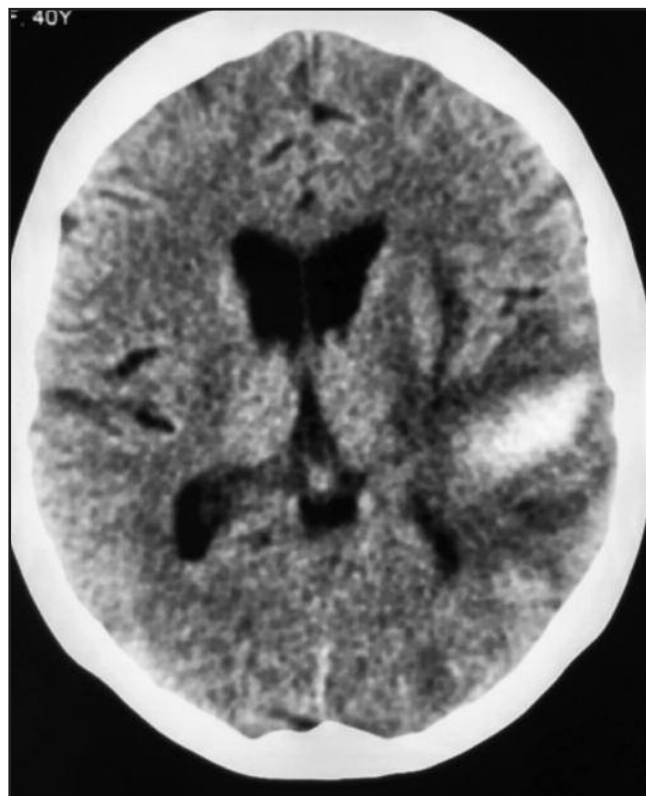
CT brain showed multifocal intracranial septic emboli (due to location at periphery and grey-white matter junction) and intraparenchymal bleed at left temporo-parietal lobe.
